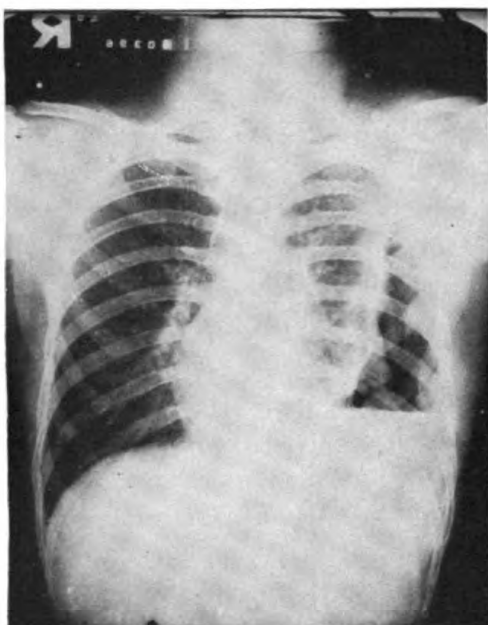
Case 1. Preoperative x-ray following aspiration of fluid from left thorax showing atelectasis, thickened pleura, fluid level, and mediastinal shift.
